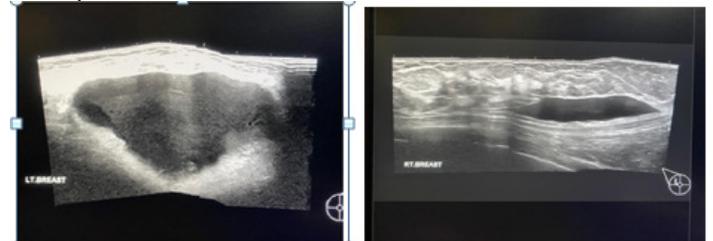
Ultrasound showed Fluid filled lesions in the both breasts, showing fluid-fluid level in left
